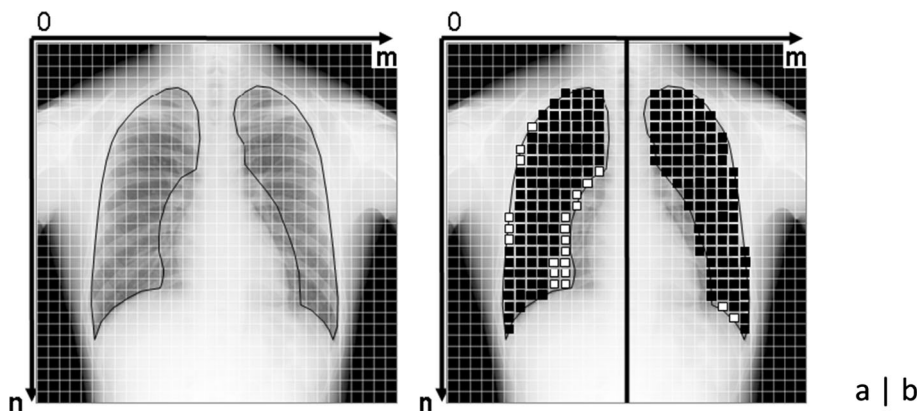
One frame of dynamic chest radiographs divided into blocks that were slightly smaller than the intercostal space. (a) The black lines show the lung area determined for the measurement of pixel values in the lungs. The hilar regions are excluded from the lung area.
